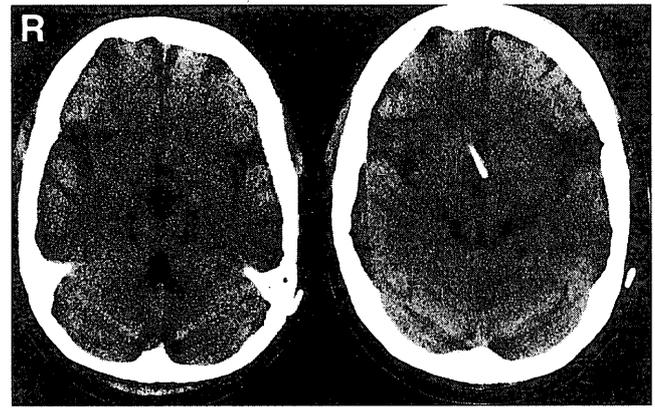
Postoperative computed tomography scans showing symmetrical reduction in the size of the ventricular system.
